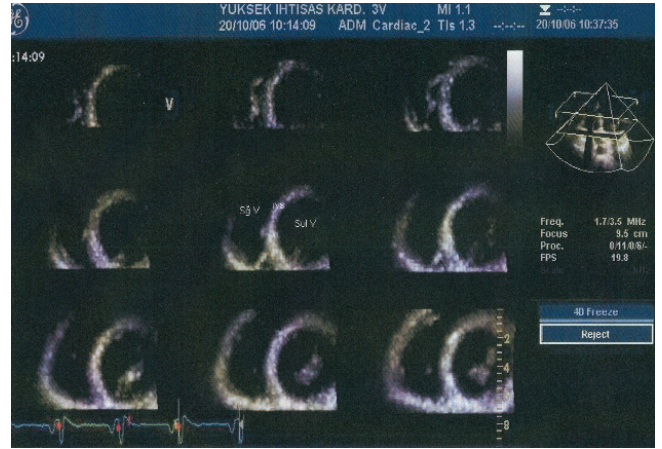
Apical to basal transversely acquired 9 slices in apical four chamber view of a normal left ventricle demonstrated by 4D echocardiography.
